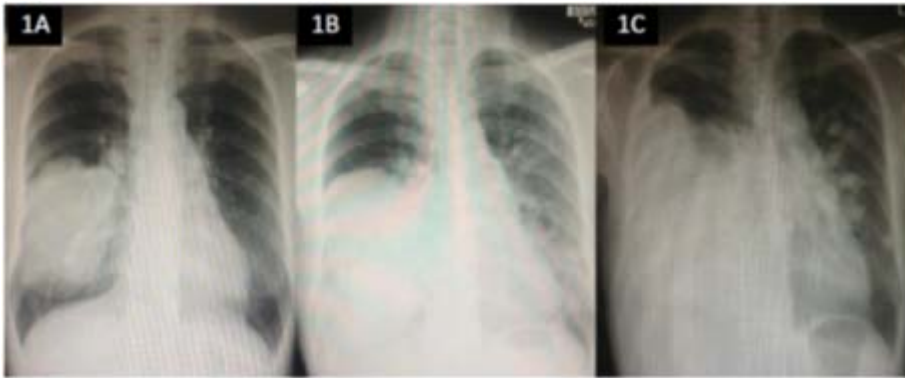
(1A)Chest radiography shows a large lobulated lung mass at the right lower lung field with prominent right pulmonary trunk; (1B) Postendarterectomy chest radiography; (1C) Postendarterectomy followed by adjuvant chemotherapy chest radiography shows the increased size of the mass with loculated pleural effusion.
